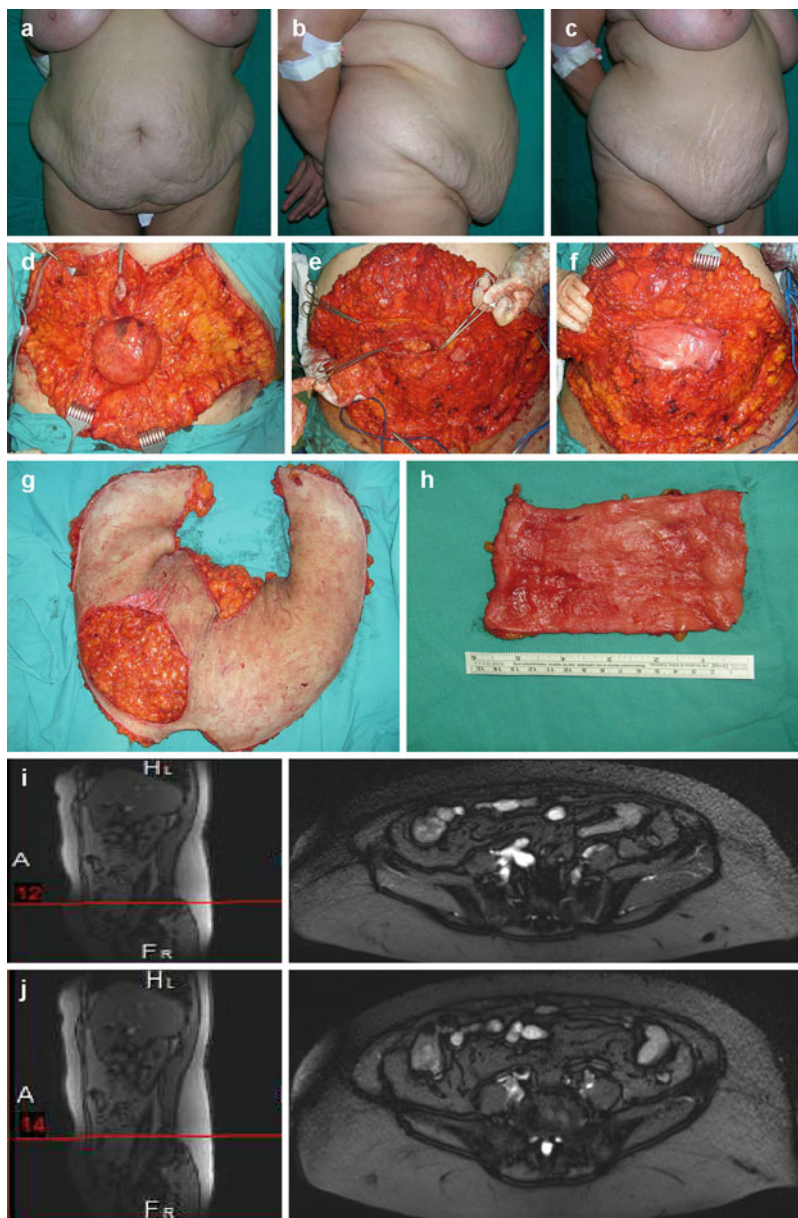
A 44-year-old woman with huge panniculi and umbilical hernia referred from the general surgery department (a–c). In the abdominoplasty operation, the hernia was repaired and the dermal automesher was applied to the defect; umbilicus was canceled. Intraoperative view of the hernia (d). Umbilicus was canceled and hernia was repaired with primary suture (e). The dermal automesher was applied over the repaired area in an onlay fashion (f). Preparation of dermal automesher from the panniculus (g) Dermal automesher (h). Postoperative third-year MRI view shows that there is no recurrence of the hernia (i, j)
